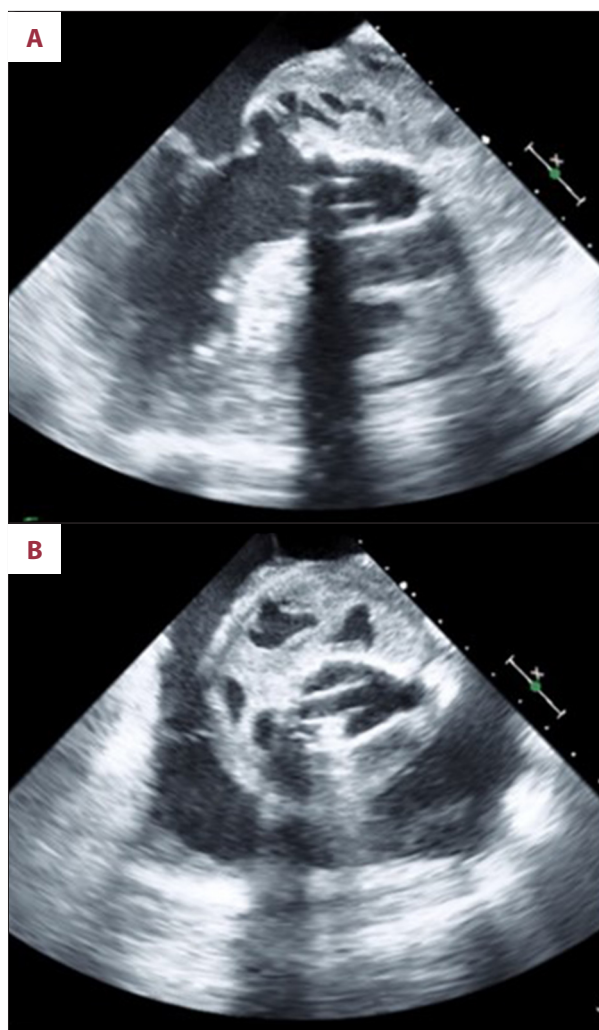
Transesophageal echocardiogram demonstrating a large mass surrounding the ascending aorta with multiple cavitations (A – short axis) and dehiscence of the intervalvular fibrosa, with a vegetation extending to the left ventricle outflow tract (LVOT) and involving the prosthetic valve (B – long axis, C – color flow showing connection between the mass lumen and the LVOT). Findings were consistent with a large infected hematoma and/or abscess.
